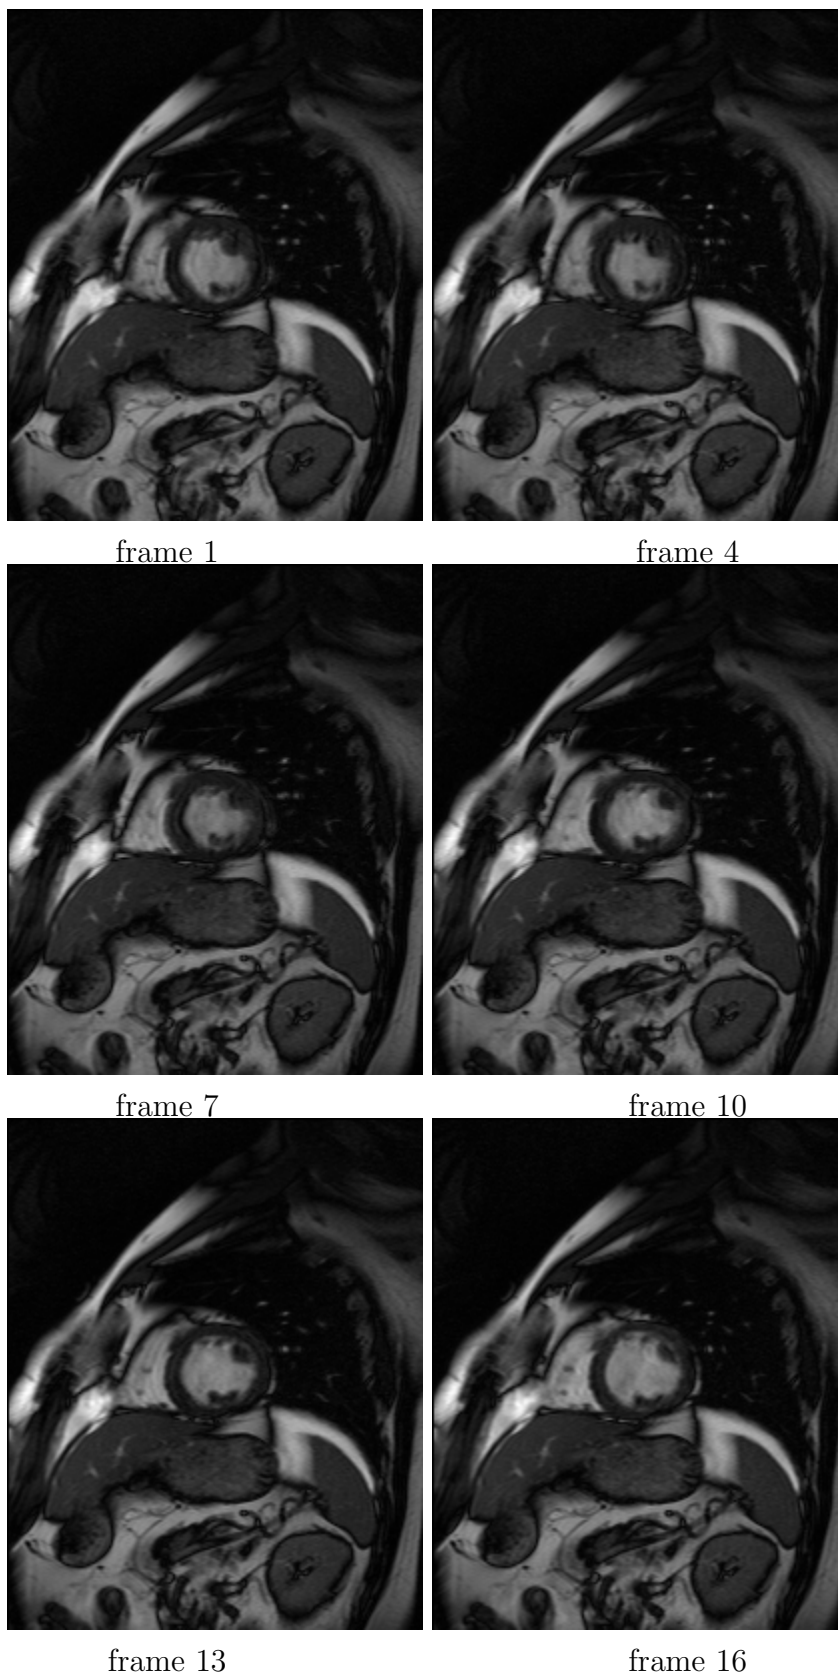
Cardiac MR images acquired at same position while different time frames
